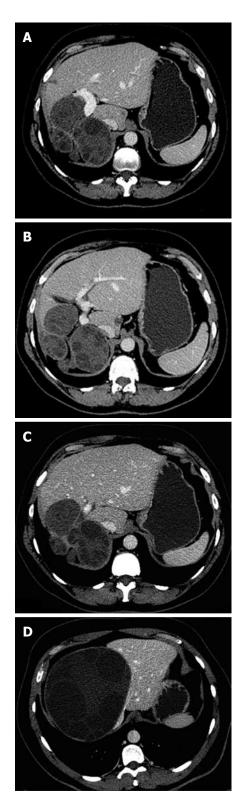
Computed tomography scan (A, B, C, D) shows some unenhanced hypoattuenuating masses with well defined borders occupying the right lobe of the liver; multiple round daughter cysts are seen peripherally inside the lesion (type II). Note the "rosette appearance".
